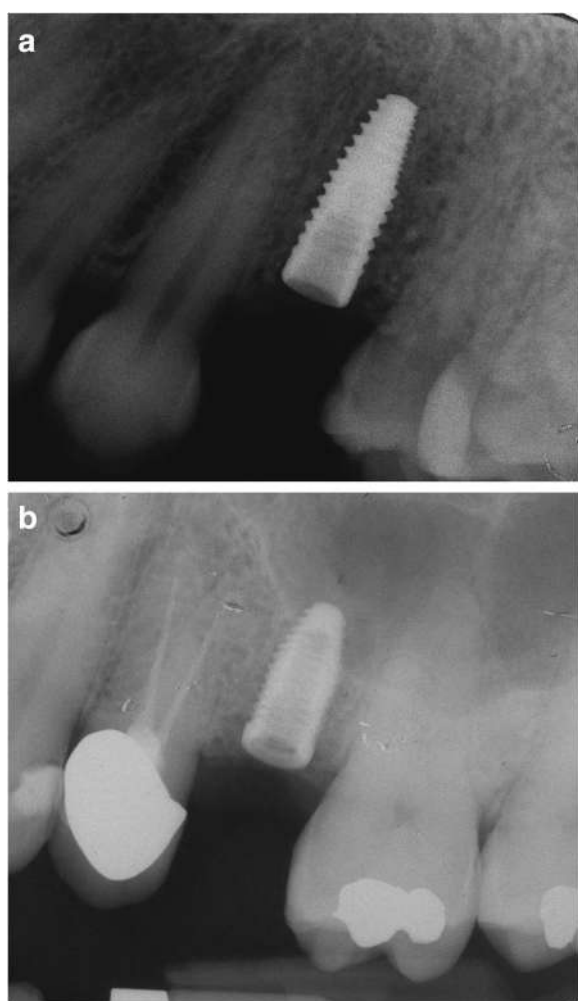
a, b: Postoperative radiographs
